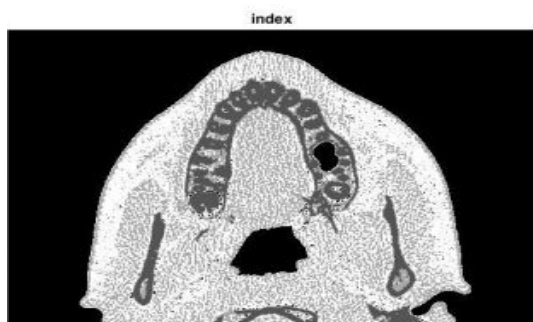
CT image after segmentation using K-means clustering method.
